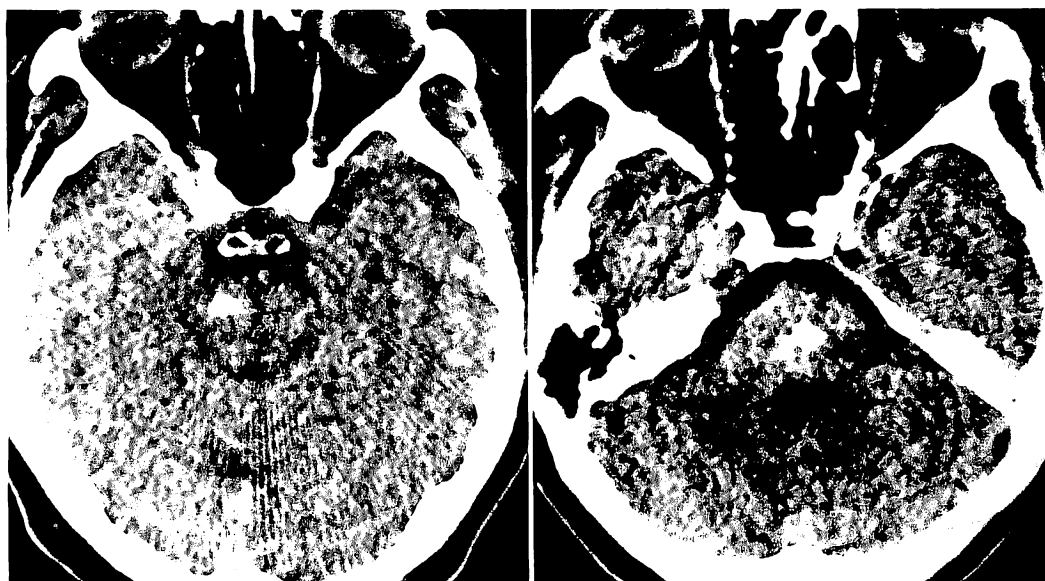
Computed tomographic images showing small hematomas located laterally (left panel) and at the very center of the pons (right panel).
